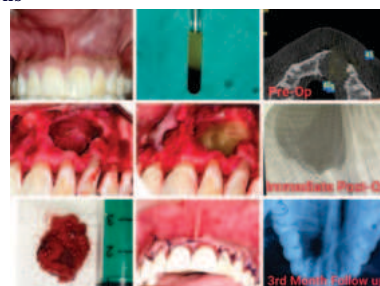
Case 4 Surgical Procedure, Intraoperative Pictures And Radiographs
